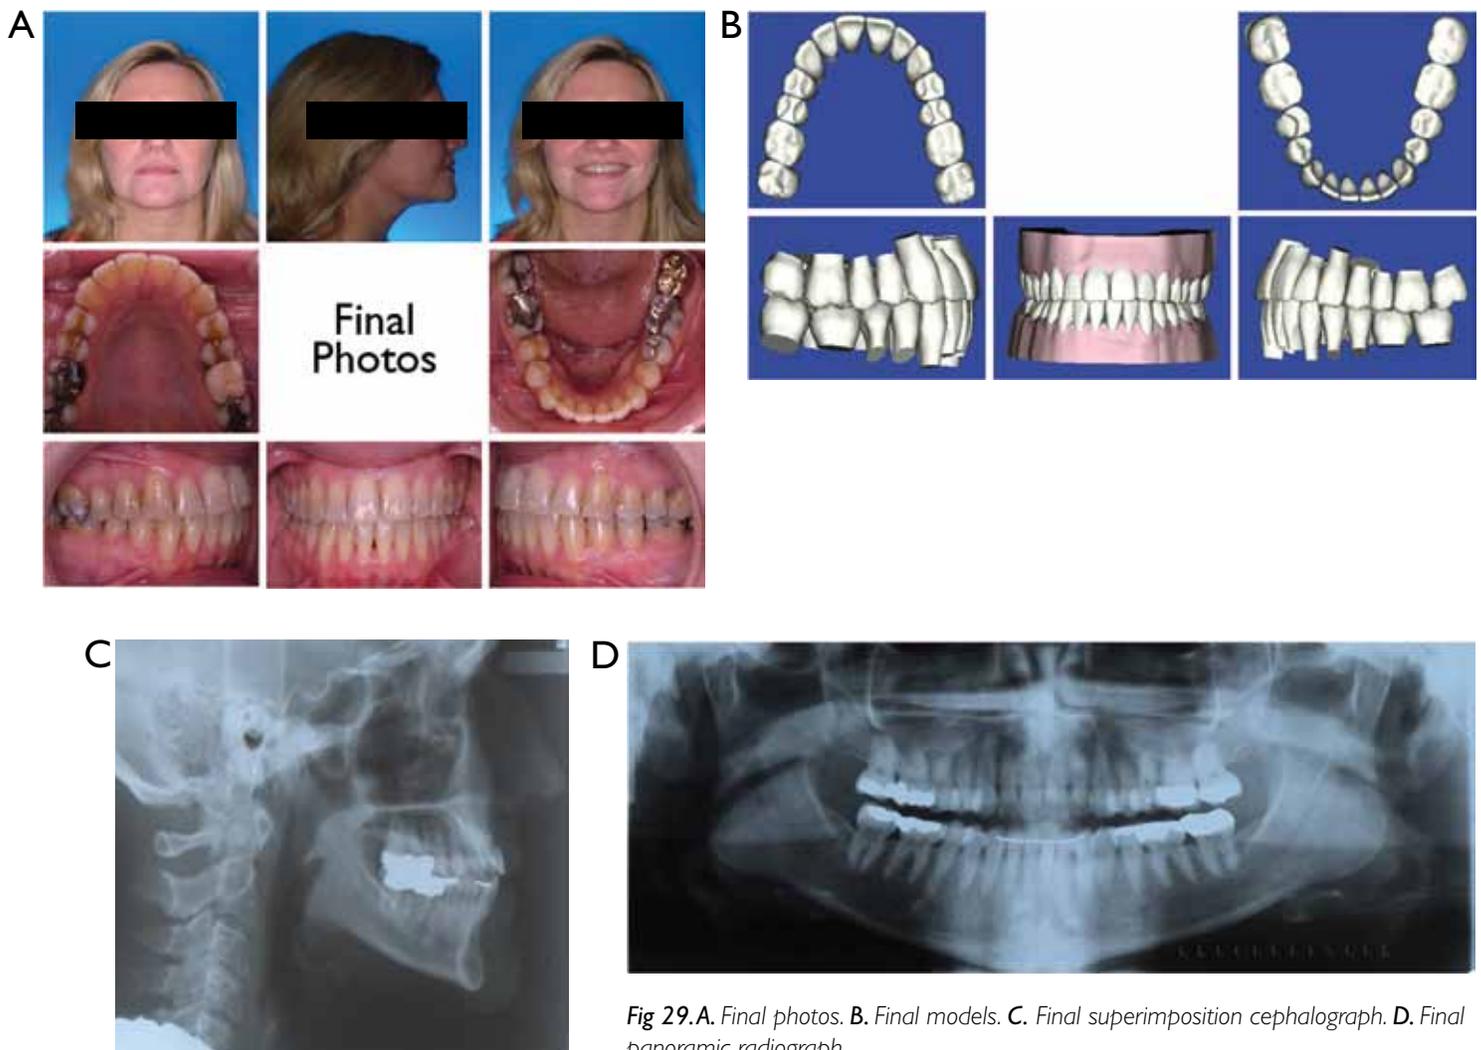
A. Final photos. B. Final models. C. Final superimposition cephalograph. D. Final panoramic radiograph
